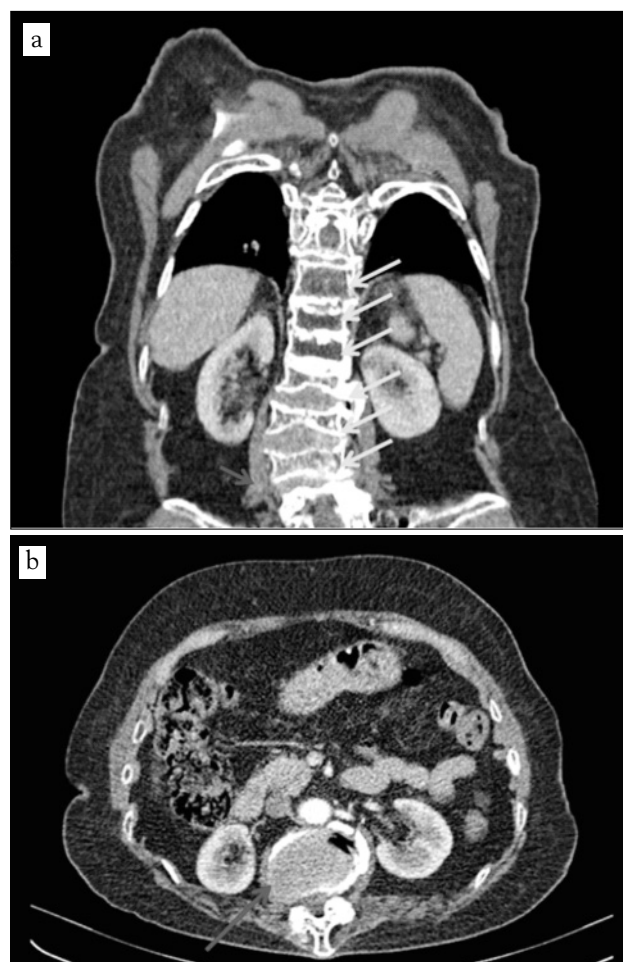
Computed tomography (CT) aspects (a) Multiple vertebral fractures (right arrows) and a sacral tumour (red arrow) in CT image (coronal plane). (b) Sacral tumour (left arrow) in CT image (transverse plane)
